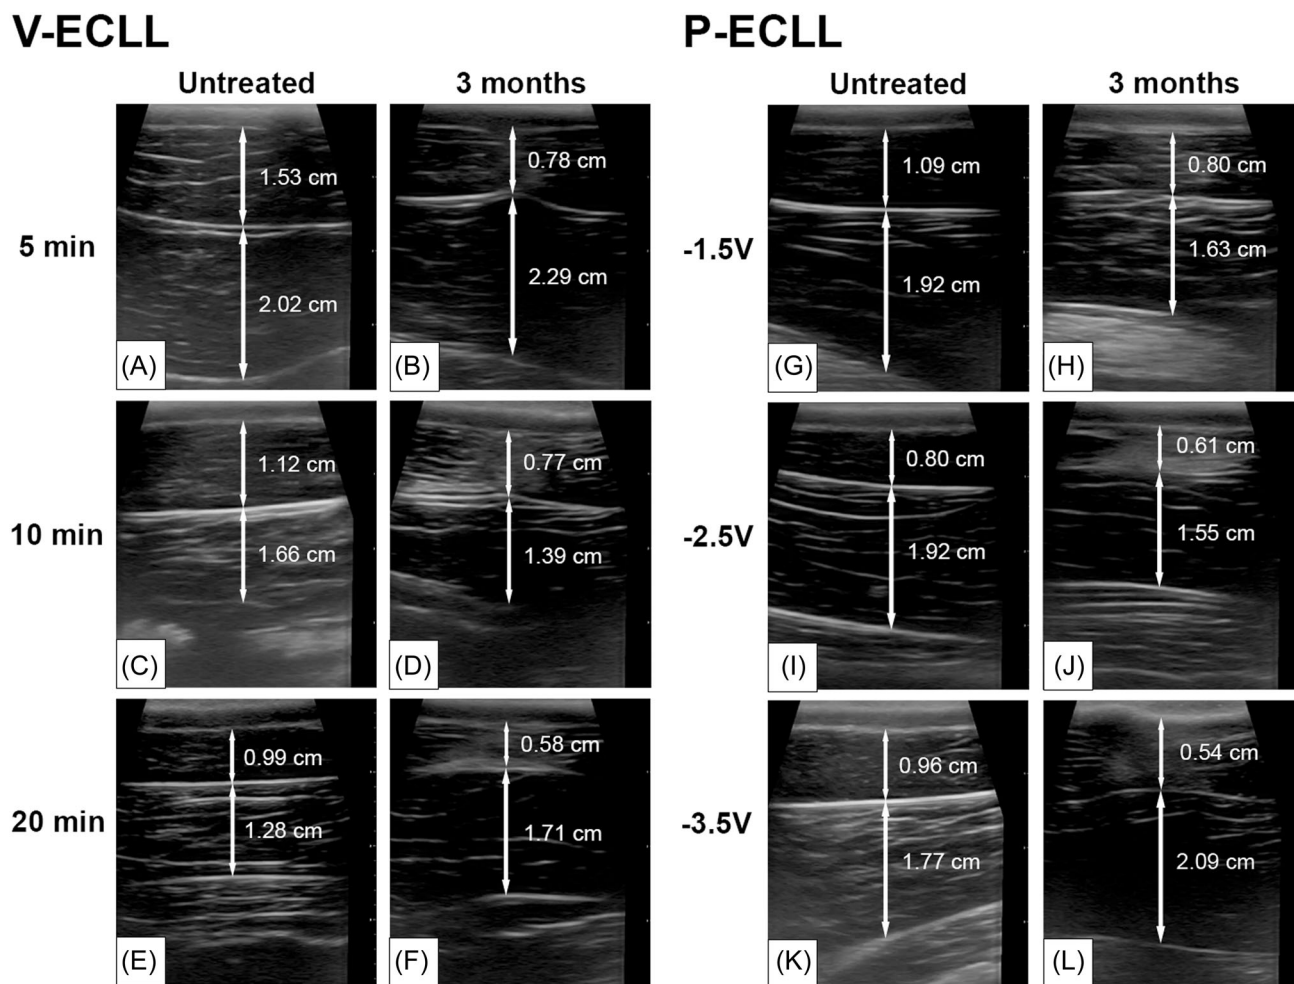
Representative ultrasound images of adipose tissue at (A–F) V-ECLL treatment sites when untreated and at the 3-month endpoint and at (G–L) P-ECLL treatment sites when untreated at the 3-month endpoint.
